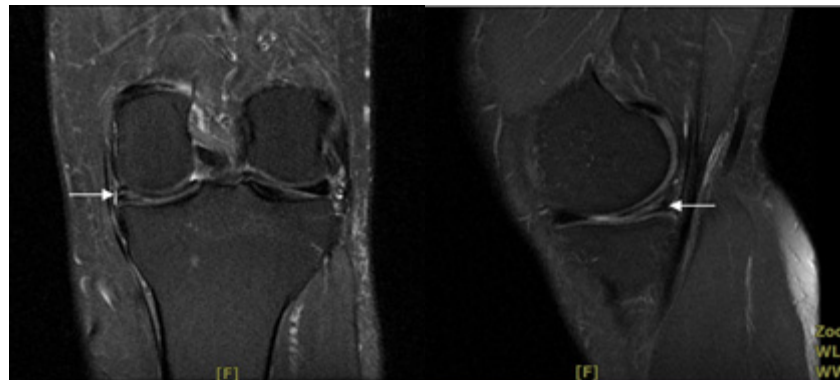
Left knee MRI of case 4 (06/15/2019).
